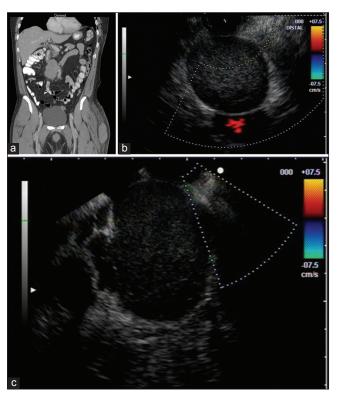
(a) Contrast enhanced computed tomography image showing well-circumscribed retroperitoneal mass; (b and c) radial and linear echoendoscopic image showing hypoechoic, heterogenous mass, abutting the wall of the second duodenum
